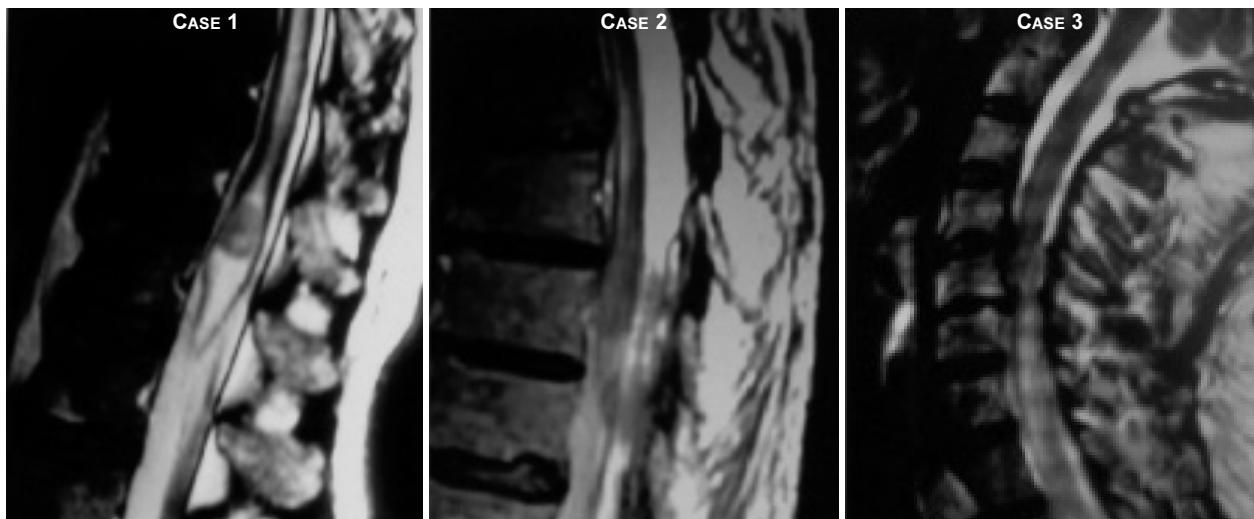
Preoperative sagittal T2-weighted MR images showing pre-operative lesions of the three cases.
